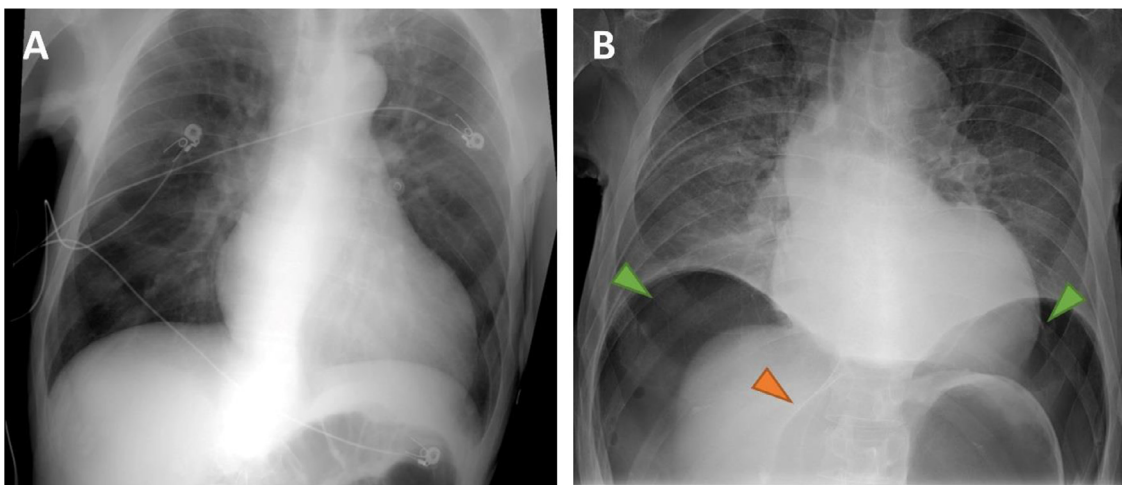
Chest radiograph obtained upon admission (A) demonstrates only mild central vascular congestion. In comparison, a chest radiograph obtained after the onset of acute abdominal pain and hypotension on hospital day 14 (B) demonstrates significant free air below the diaphragm (green arrowheads) and the falciform ligament sign (orange arrowhead) consistent with pneumoperitoneum.
